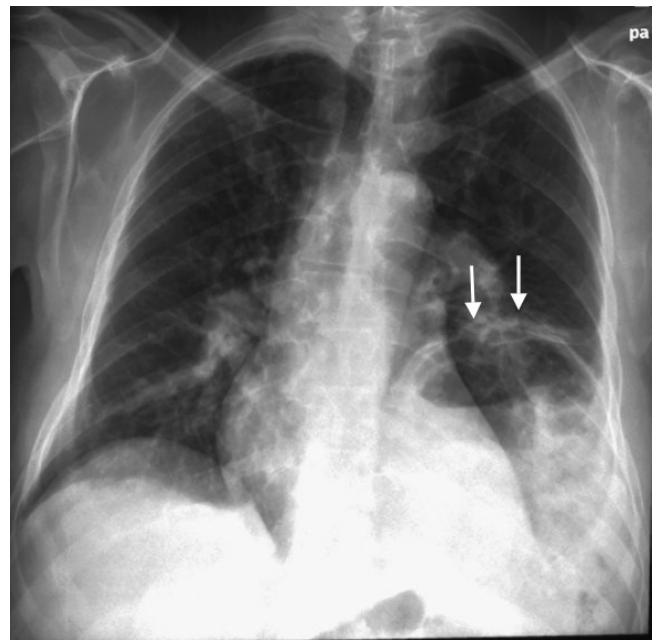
Frontal chest radiograph demonstrating an elevated left hemidiaphragm (arrows) in keeping with eventration.
